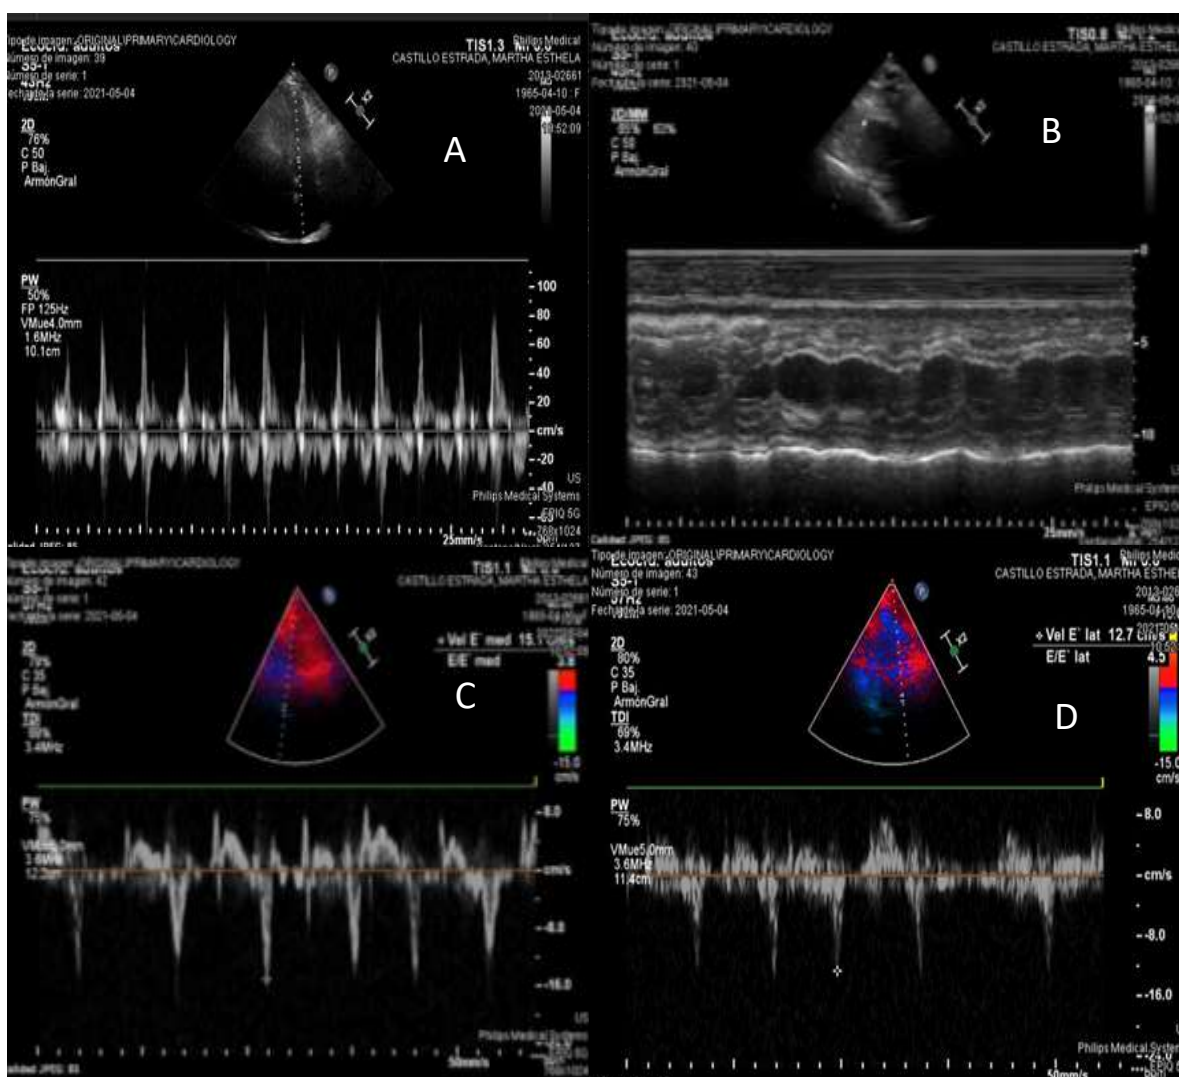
Transmitral Doppler showing variation with respiration (A), M mode showing abnormal septal movement (B), tissue Doppler of the lateral ring with $E' > 12 \text{ cm/s}$ (Cy D)
